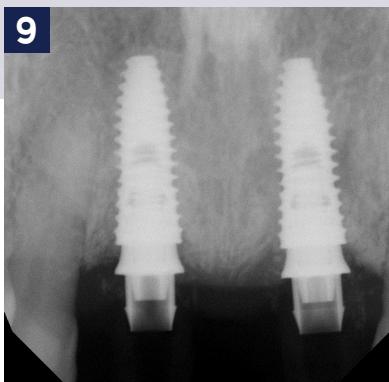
A periapical radiograph of the implants showing bone growth and maintenance, and verifying the full seat of scan bodies.
